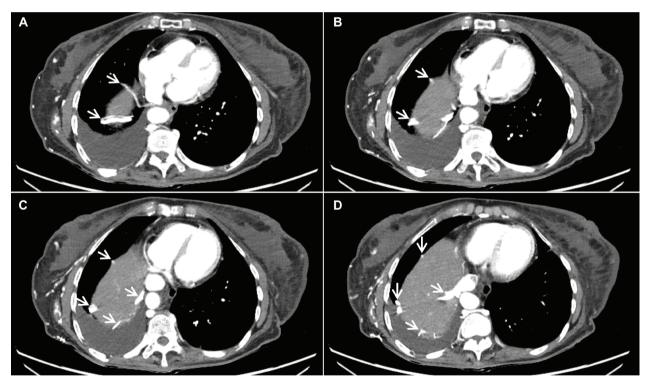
Serial axial view of the chest CT image (A to D) showed 3 phrenic venous routes that passed through the liver surface.
